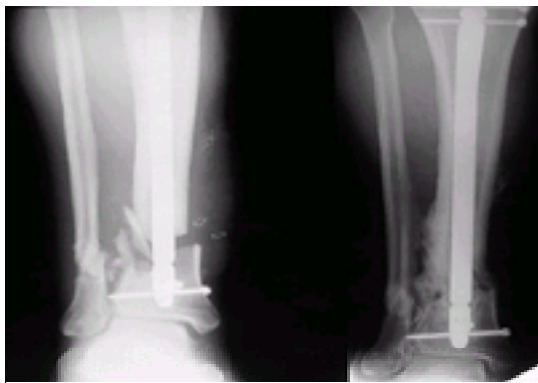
Example of a displaced, grade IIIB open fracture of the tibia, managed by intramedullary nailing, free tissue transfer, and staged bone grafting. On the left, an anteroposterior radiograph of the injured tibia immediately after intramedullary nailing. With the nail in place, management of the associated soft-tissue injury was facilitated. Note the segmental bone loss present. On the right an anteroposterior radiograph taken 1 year after injury, following staged posterolateral and anteromedial autogenous bone grafts. The fracture has united and the patient is able to walk normally.
